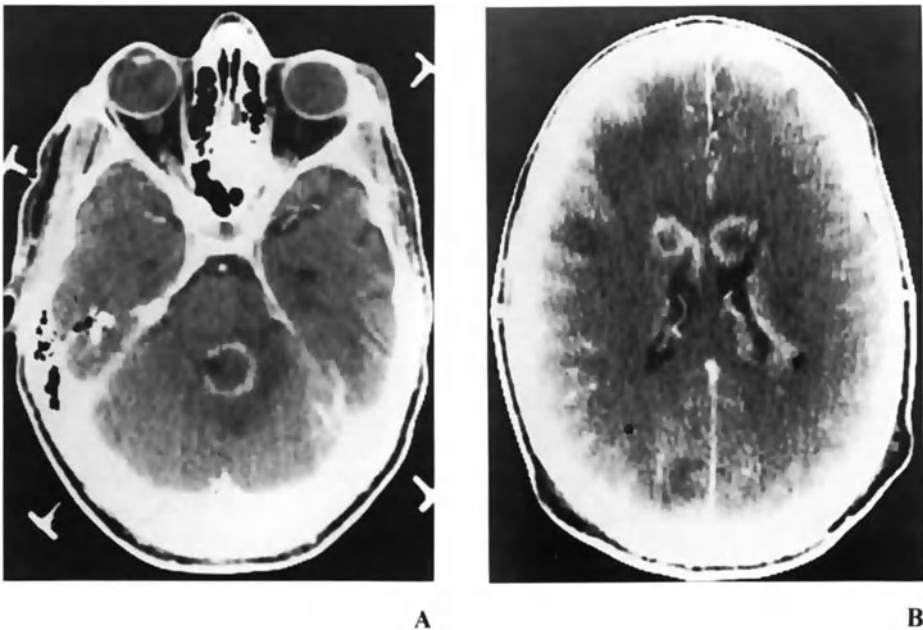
Primary CNS lymphoma (A, B) CT scans from a 53-year-old gay man with AIDS shows multiple enhancing lesions in the cerebrum and brain stem. Note the subependymal tumor spread (arrow), which helps differentiate the lesions from *Toxoplasma* abscesses
